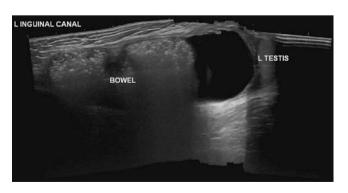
Ultrasound scan of inguinal canal with herniated bowel loop in a child
